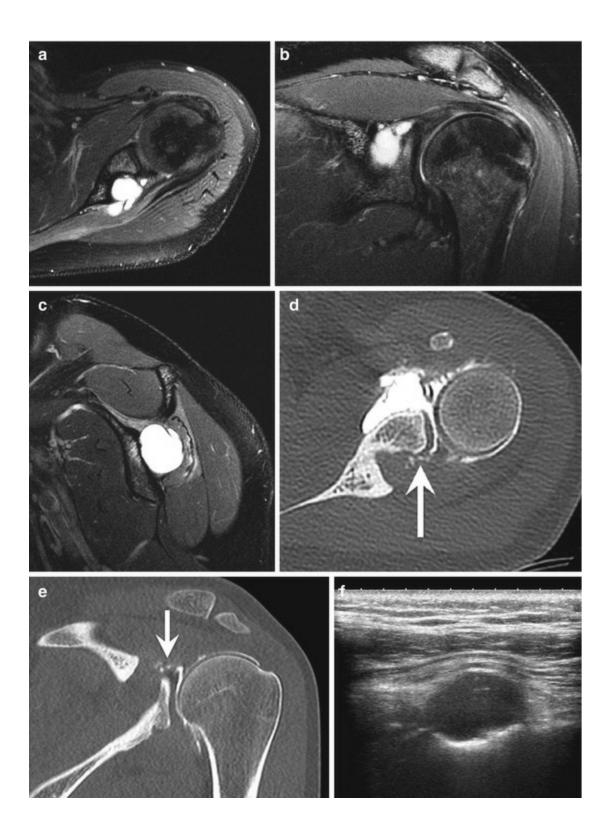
A 28-year-old woman with a spinoglenoidal cyst and a posterosuperior impingement of the shoulder. (a) Axial, (b) coronal and (c) sagittal fat-suppressed T2-weighted MRI show a large cyst of the spinoglenoidal notch responsible for compression of the suprascapular nerve. Note the muscle atrophy and edema of the infraspinatus muscle. MRI also shows some heterogeneity of the posterosuperior labrum with a suspicion of a tear. (d) Axial and (e) coronal reformatted CT arthrography images clearly demonstrates the posterosuperior labral tear connecting with the cyst (arrow). Due to its highly viscous content, the cyst is not completely filled by the contrast medium. (f) Short axis ultrasound image shows the cyst. (g) Picture shows the gelatinous aspect of the cyst content
